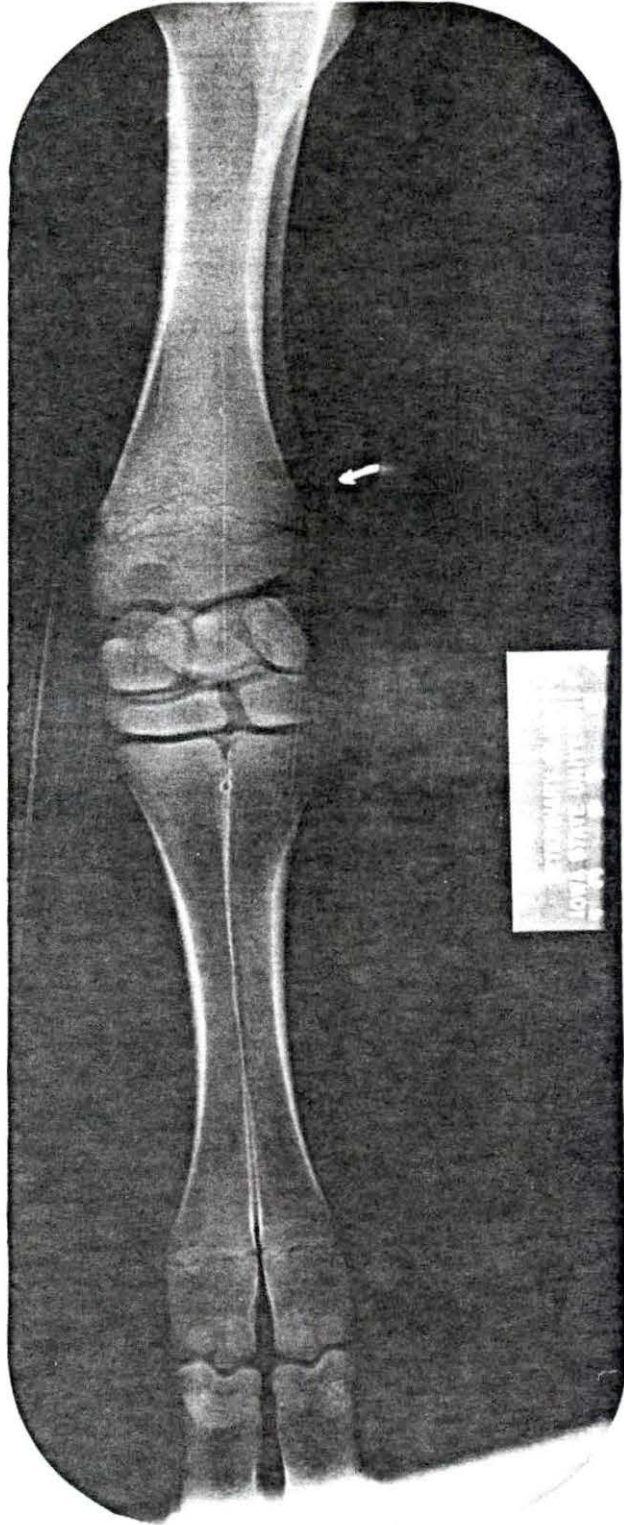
An enlargement of the radiograph in Figure 5. A photograph of a radiograph of the carpus of experimental calf number 13. This calf was given 1,250,000 I.U. of vitamin D₂ per day for 28 days. Note the outlined irregular triple lines of density in the epiphyseal zone and the increased density on the epiphyseal side of the ulnar gap (arrow)
